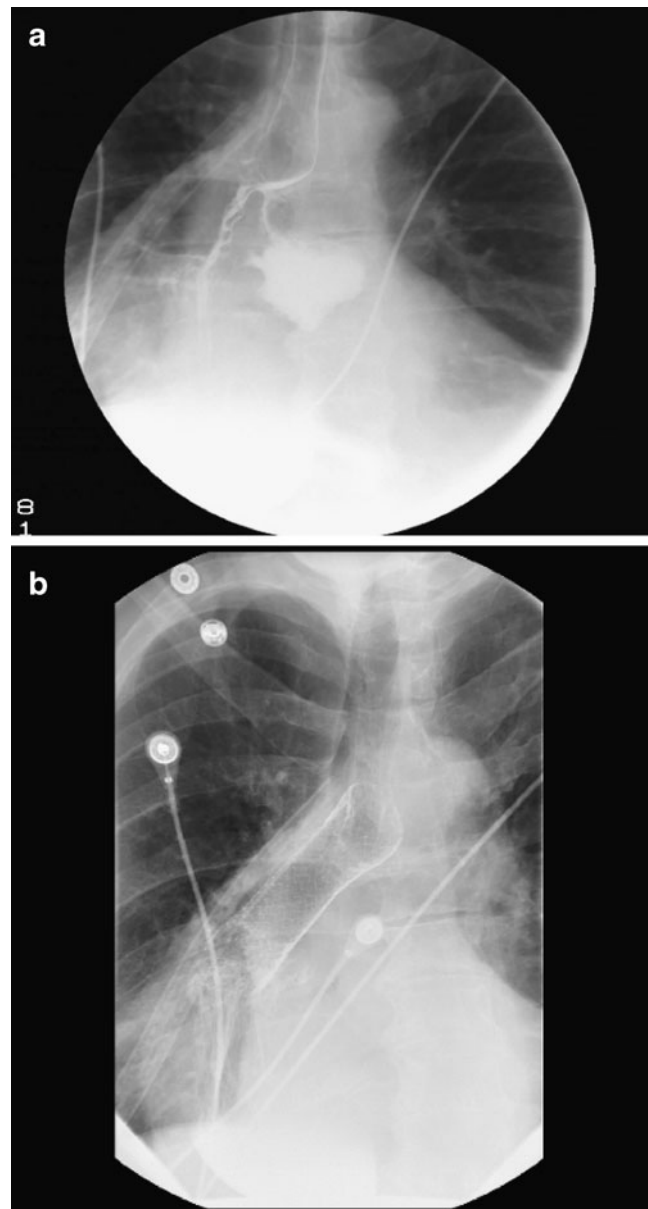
a Upper gastrointestinal contrast study on postoperative day 5 demonstrating an anastomotic leak into a contained mediastinal collection. b Chest X-ray following endoscopic drainage of mediastinal collection and deployment of a covered esophageal stent
